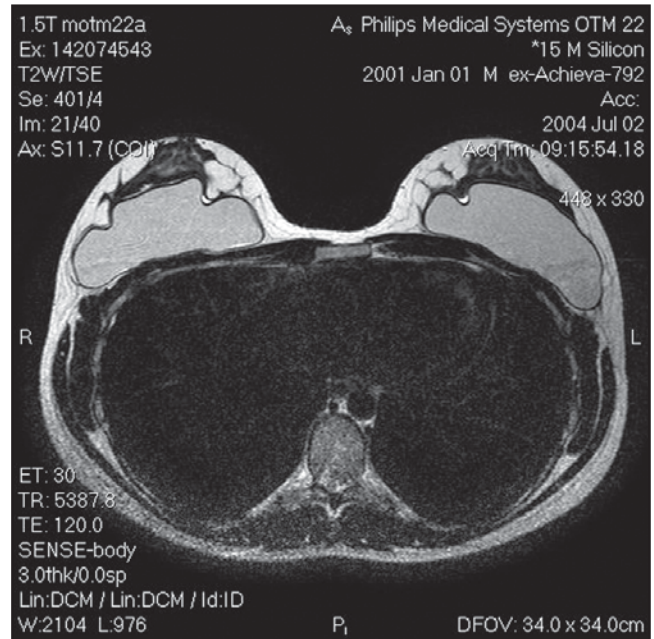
T2-weighted magnetic resonance bilateral study of silicon breast implants with sensitivity encoding (SENSE) imaging at 1.5 T field strength. This is image 22 of 40. (Image courtesy of Philips Medical Systems, Bothell, Wash.)
